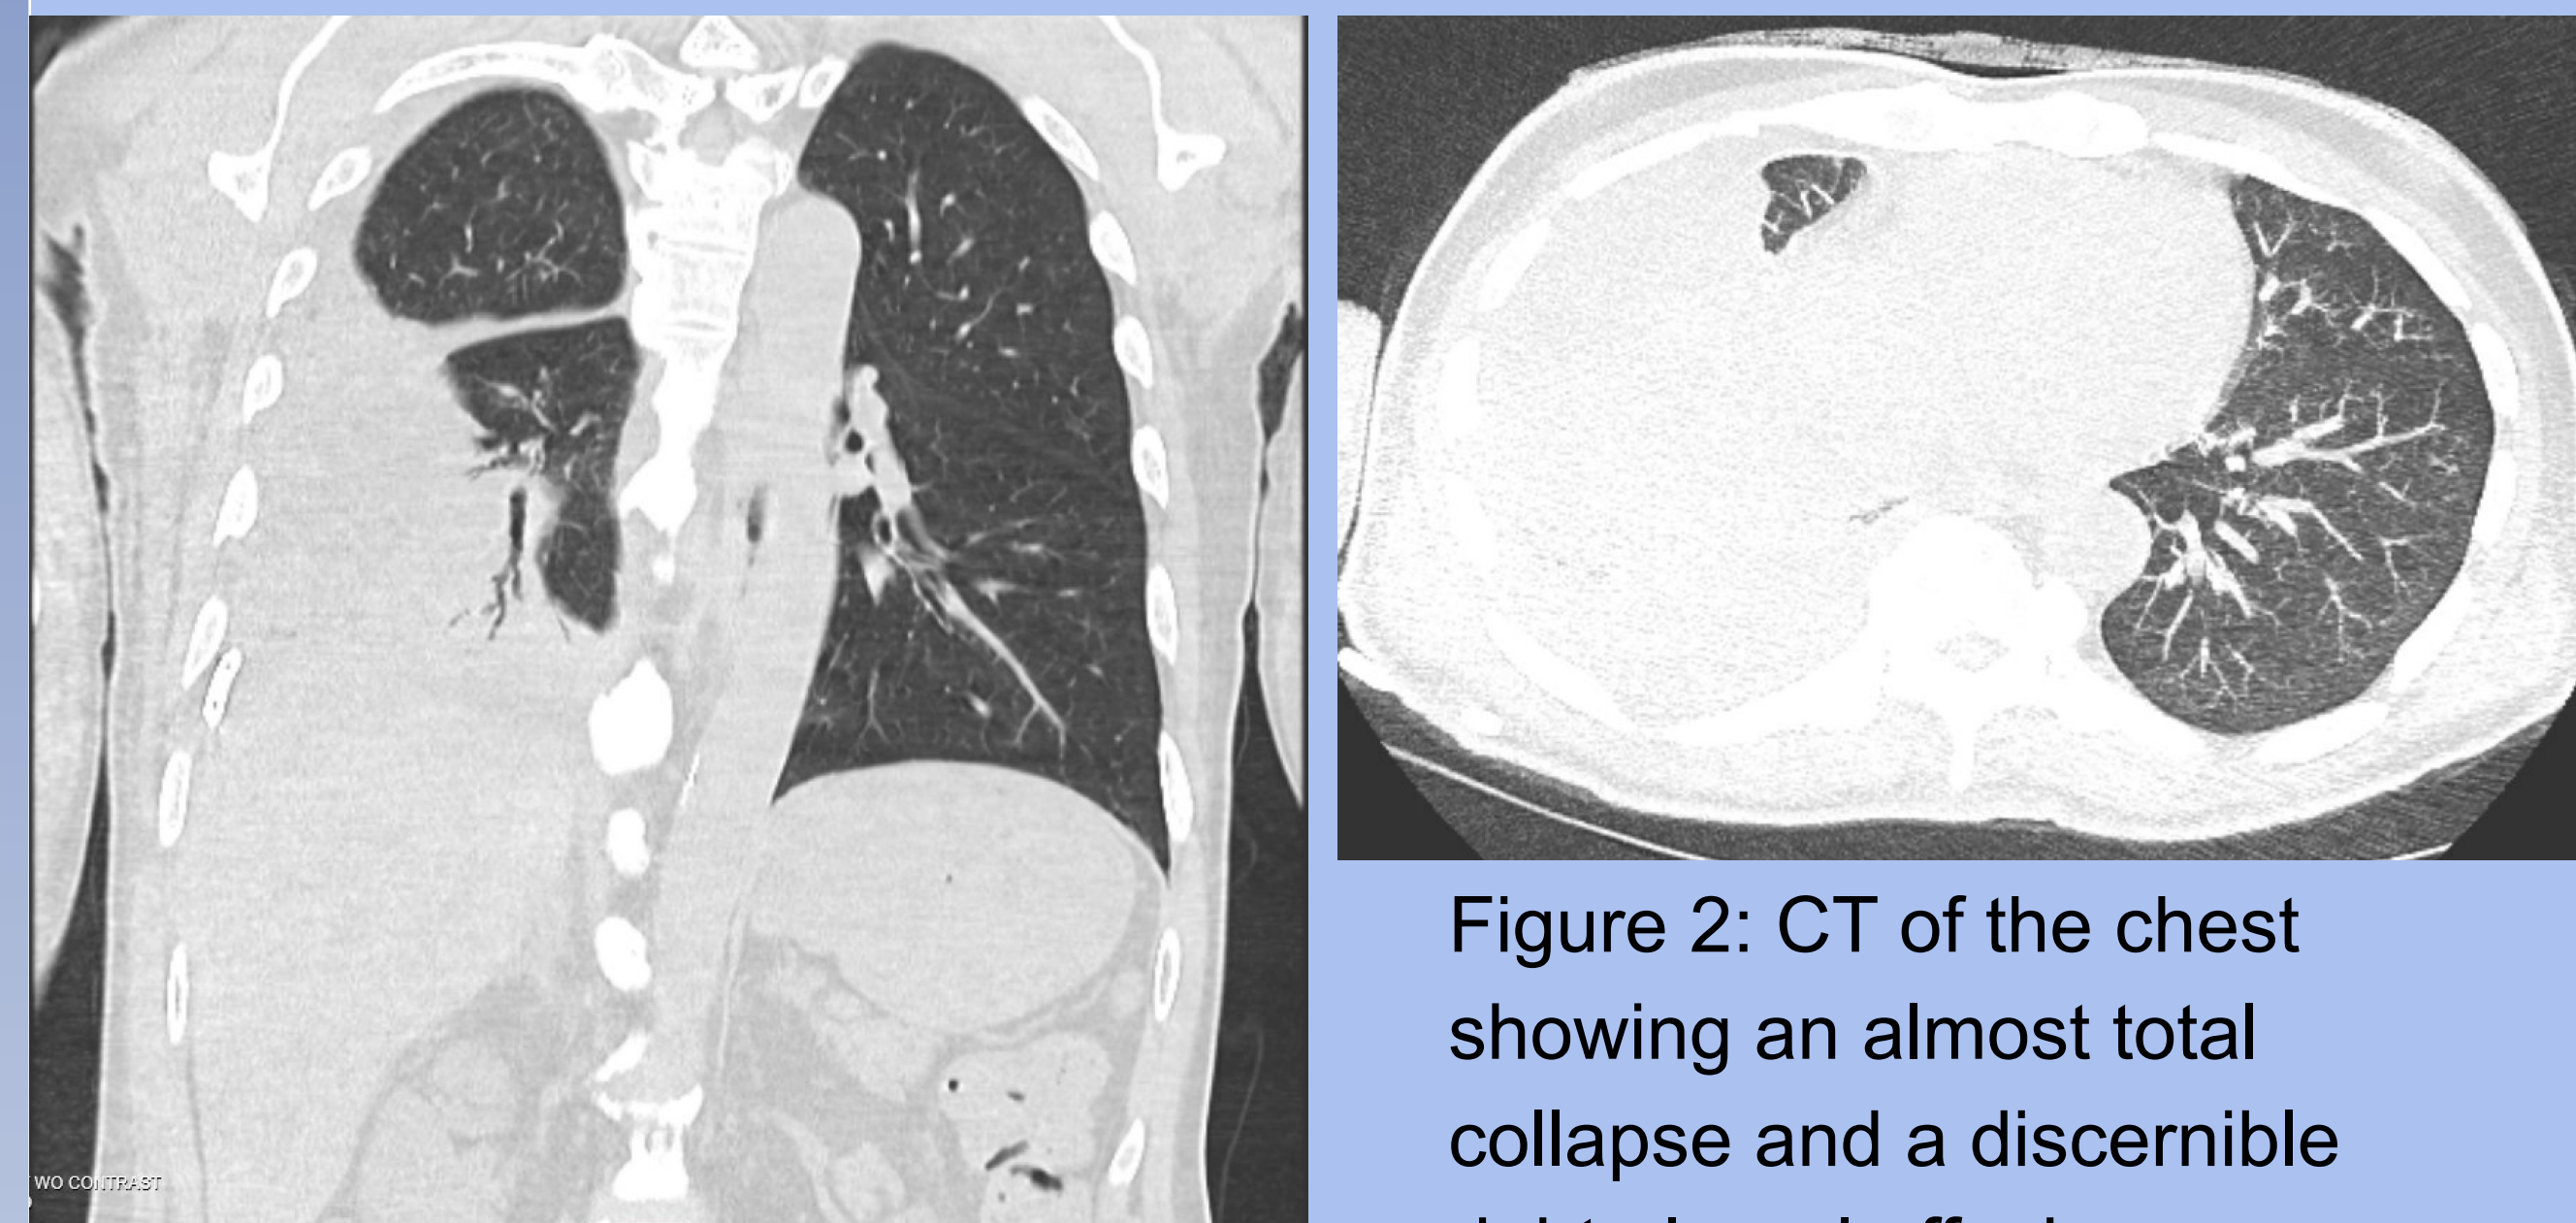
CT of the chest showing an almost total collapse and a discernible right pleural effusion
